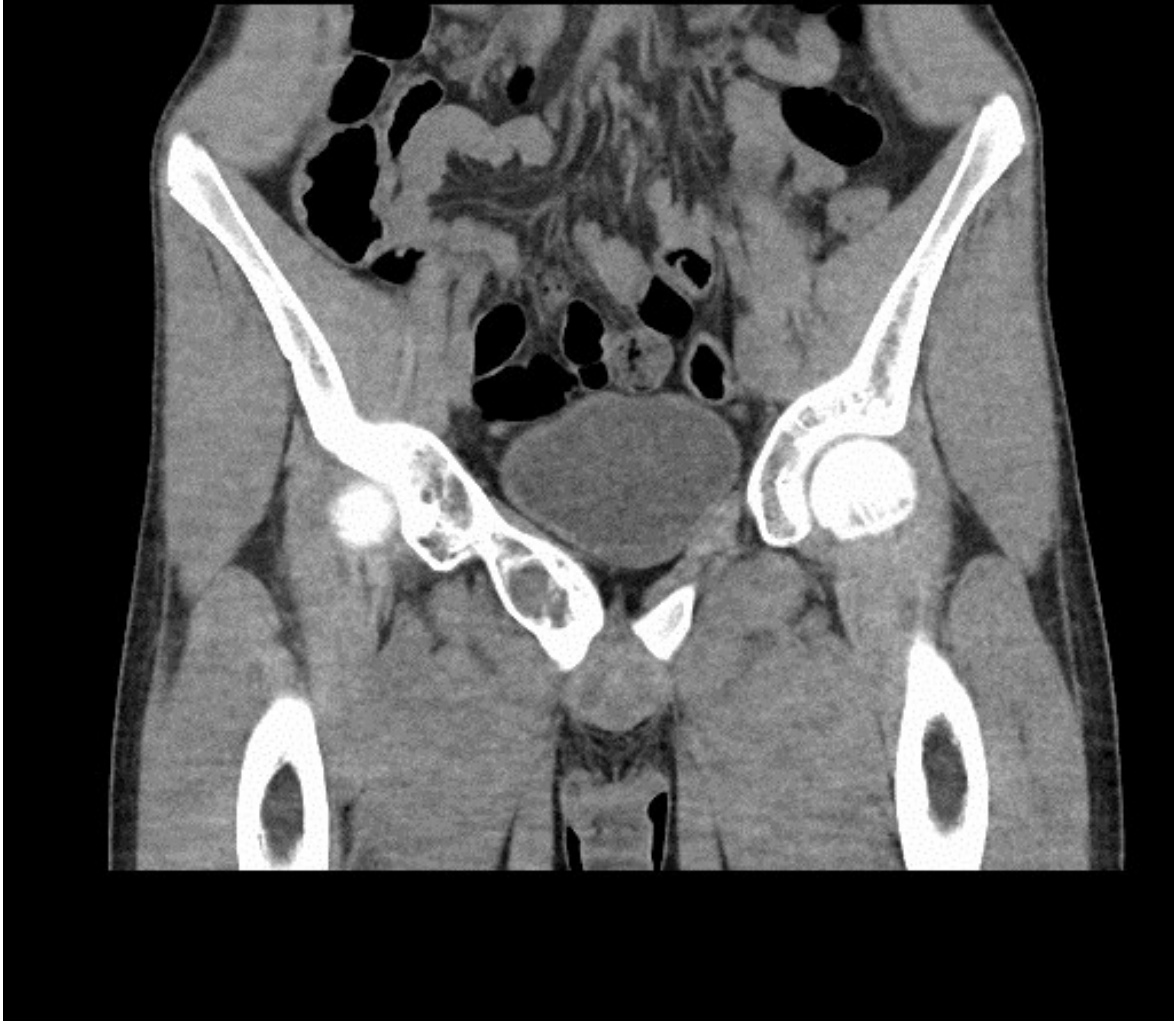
CT of an ES in the right os pubis of a 16-year old boy.
